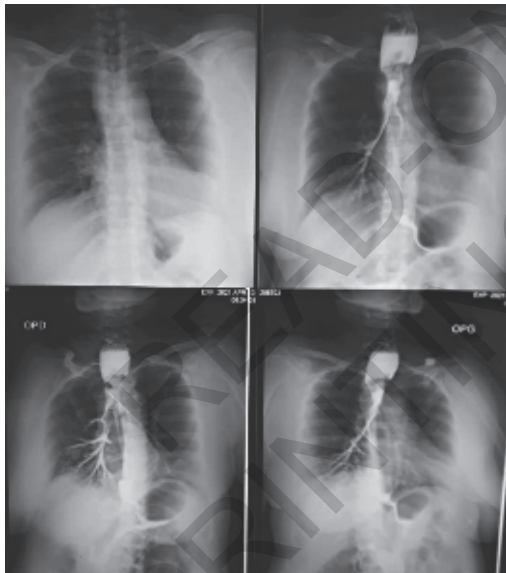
Oesophagus X-Ray with gastrograhpyn. Demonstrated the passage of gastrograhpyn from pharyngeal esophagus to trachea.
